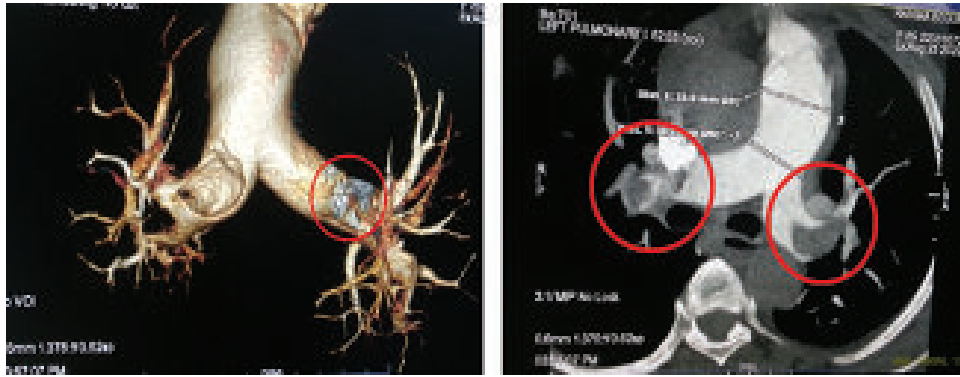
CT pulmonary angiogram showing multiple filling defects in both distal Right & Left pulmonary artery, lobar and segmental branches suggesting thrombus.
